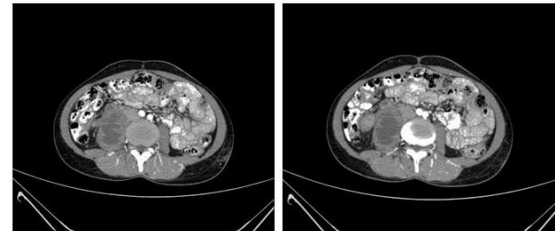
Contrast enhanced axial CT sections showing bulky right psoas as compared to left. A thick walled peripherally enhancing necrotic collection involving right psoas muscle is seen. Features are s/o right psoas abscess.
